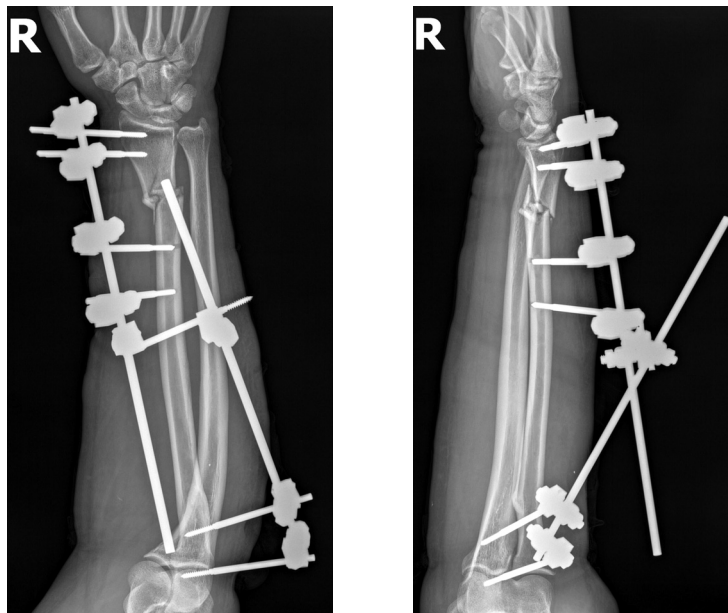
X-ray image of the injured limb with an external fixator on the first day of injury
